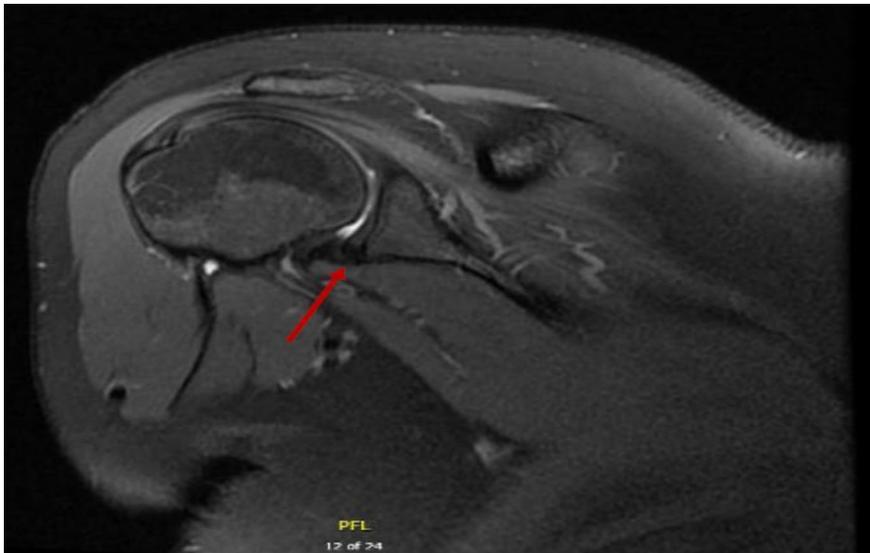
MRI of right shoulder (Coronal) showing a Bankart lesion.
